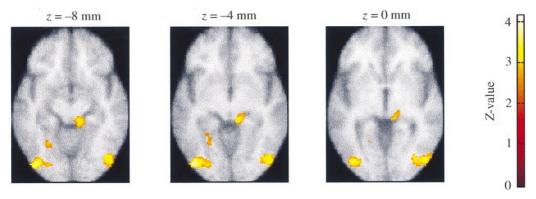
A statistical parametric map displaying brain regions with an increased contribution from the left amygdala during the presentation of fearful faces (see Table 3A and Fig. 5). Transverse slices at z=0, -4 and -8 mm are displayed using the mean structural MRI image from all five subjects. Bilateral areas of inferior occipital gyri are clearly shown in all slices. Other significant regions in the -4 and -8 mm slices include fusiform and hippocampal gyri and the right dorsal midbrain. In the z=0 mm slice the right pulvinar is shown as a significant region. An uncorrected P-value of 0.01 was used as the threshold for the contrast.
